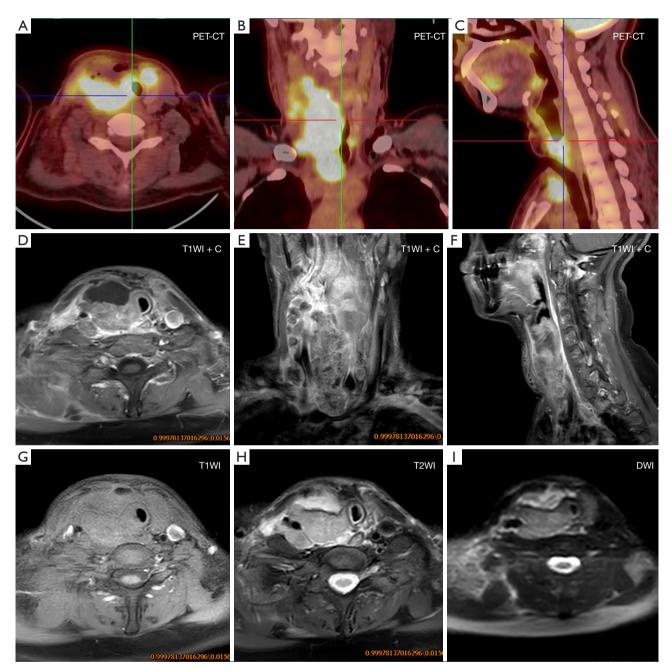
PET-CT and enhanced MRI of the thyroid tumor. (A-C) Axial, coronal and sagittal PET-CT images of the mass postoperatively. (D-F) Axial, coronal and sagittal MRI (T1WI + C) images of the mass postoperatively. (G-I) Axial MRI images of T1WI, T2WI and DWI sequences of the mass postoperatively. PET-CT, positron emission tomography-computed tomography; MRI, magnetic resonance imaging; T1WI + C, contrast-enhanced T1-weighted imaging; T2WI, T2 weighted image; DWI, diffusion-weighted imaging.
